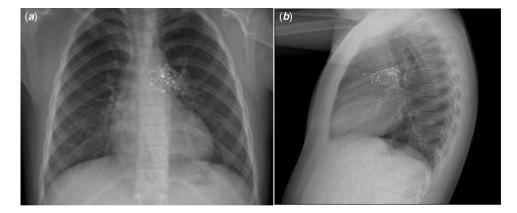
Chest X-ray A: Posteroanterior protection B: Lateral protection. Showing an adequate position of the device, with normal pulmonary vasculature.
